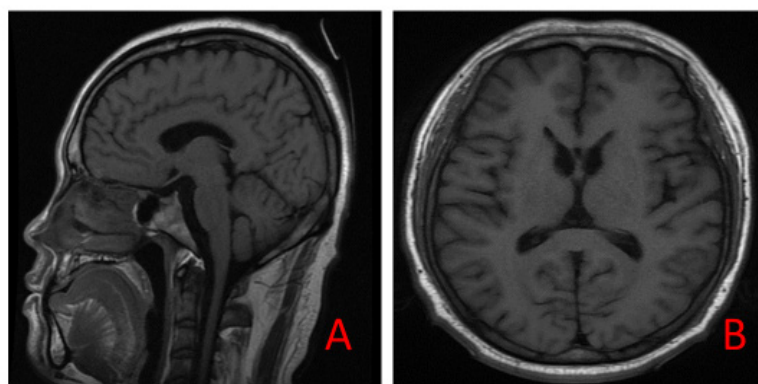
Brain MRI of the proband demonstrating normal structural appearance: (A) Axial T2-FLAIR images; (B) Sagittal T1-weighted images. No evidence of cobblestone lissencephaly, cerebellar cysts, or white matter abnormalities is detected.
